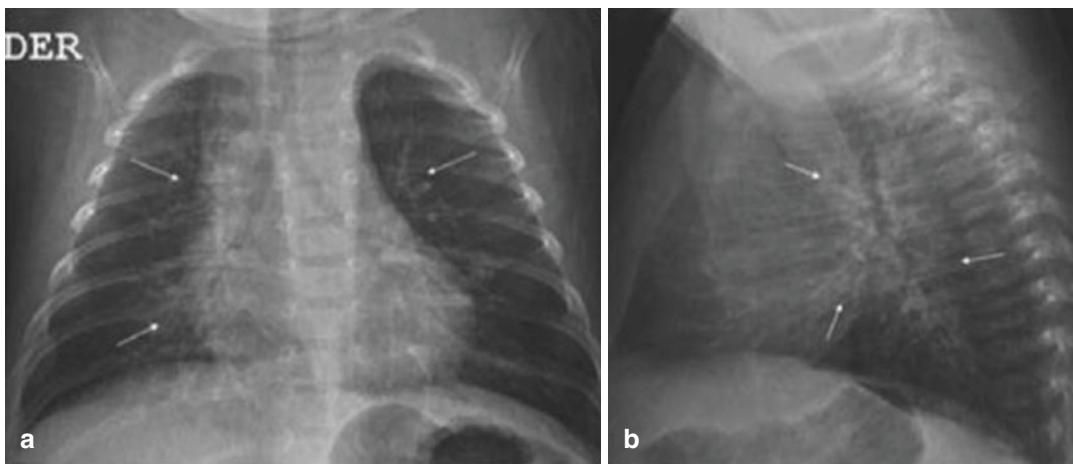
Interstitial pneumonia in a 6-month-old infant with a cough and fever. Chest x-rays in the anteroposterior (a) and lateral (b) views show interstitial shadowing in the central regions of both lungs (arrows)
